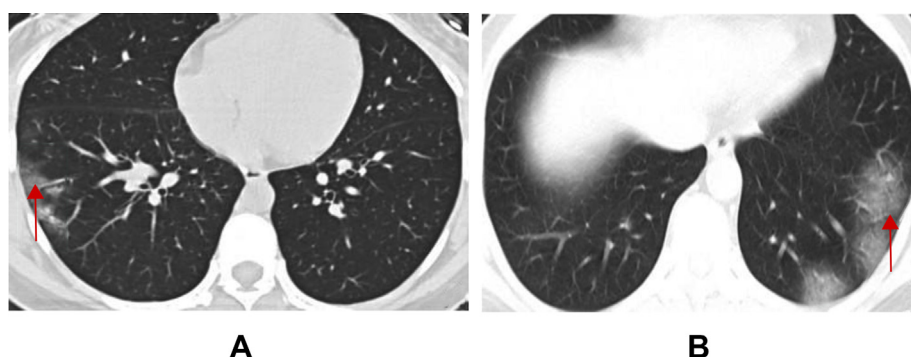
Female patient, 30 years old, clinical symptoms are not typical, CT examination; image shows ground-glass exudation in both lungs (see the red arrows).
